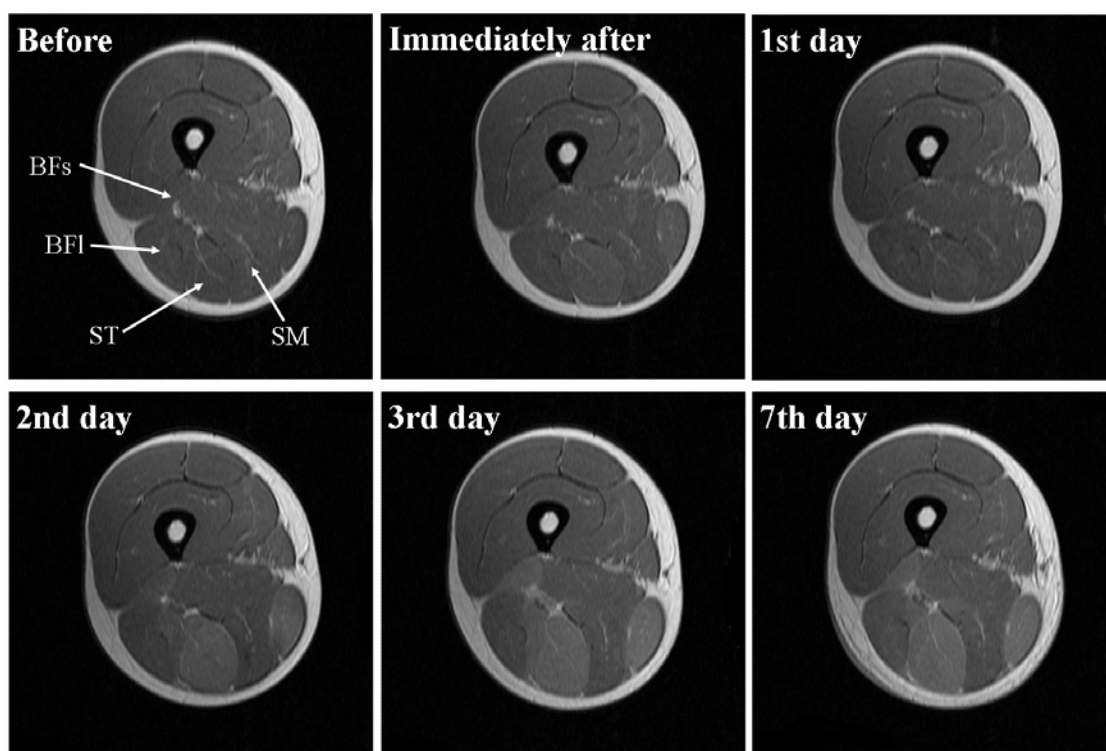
Representative T2-weighted magnetic resonance images of the middle region (50% of thigh length) from one subject before, immediately after, and on the 1st, 2nd, 3rd, and 7th days following eccentric exercise. *BFfs* biceps femoris short head muscle, *BFl* biceps femoris long head muscle, *ST* semitendinosus muscle, *SM* semimembranosus muscle.
